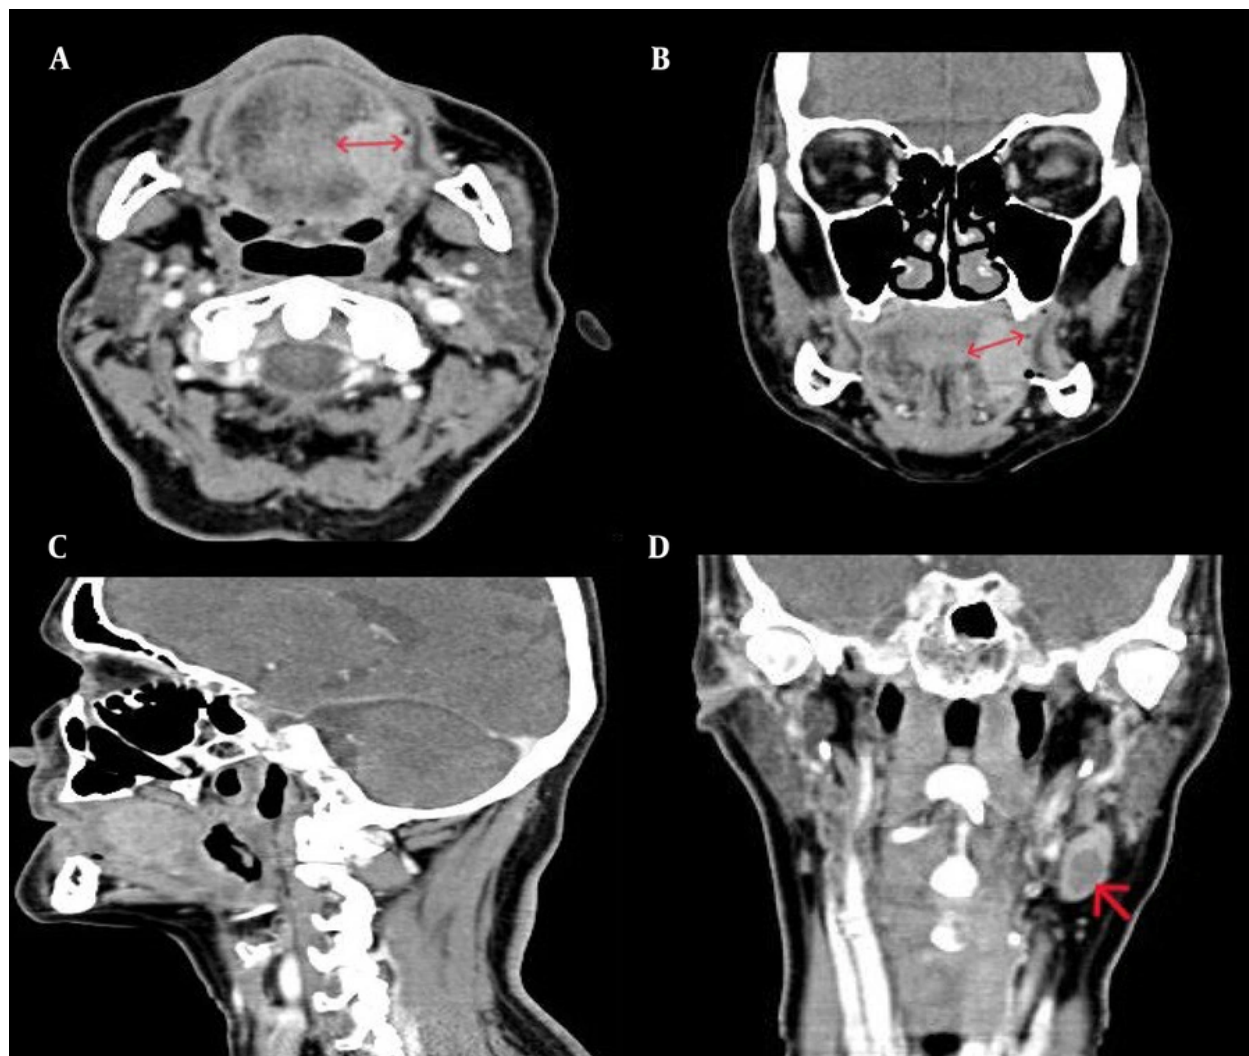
Contrast-enhanced computed tomography of a 60-year-old man with lateral tongue squamous cell carcinoma. Red lines indicate rDOI measurement in the axial (A) and coronal (B) planes: a perpendicular line from the proposed normal mucosal baseline to the deepest point of tumor invasion. In this case, the measurement was approximately 17 mm in both coronal and axial planes; however, the plane showing the greatest DOI is preferred for measurement. The sagittal plane (C) is not representative of maximum DOI in laterally located tongue squamous cell carcinoma. pDOI = 16 mm; rDOI by Radiologist 1 = 17 mm; rDOI by Radiologist 2 = 17.5 mm. The red arrow in the coronal plane (D) shows necrotic lymphadenopathy at level II of the left cervical chain in the same patient.
